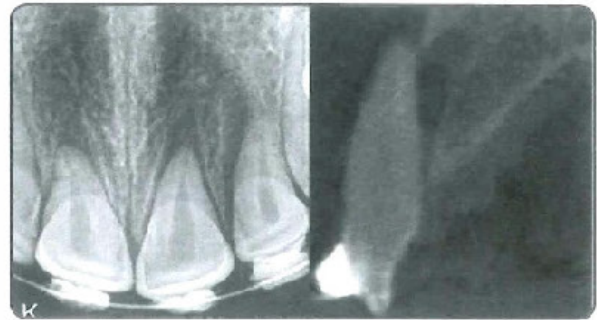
Periapical radiograph of upper centrals and left lateral incisors, that had recently been splinted in an emergency room. CBCT Sagittal view imaging of the lateral incisor revealed how severe the displacement was.
